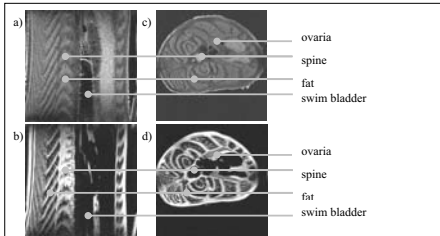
MRI with a 5.6 Tesla magnet (300 MHz) of eel showing where fat is stored with a) water image longitudinal, b) fat image longitudinal, c) water image cross-sectional and d) fat image cross-sectional. (Performed in collaboration with Prof. Dr. Annemie van der Linden, University of Antwerp, Belgium).
